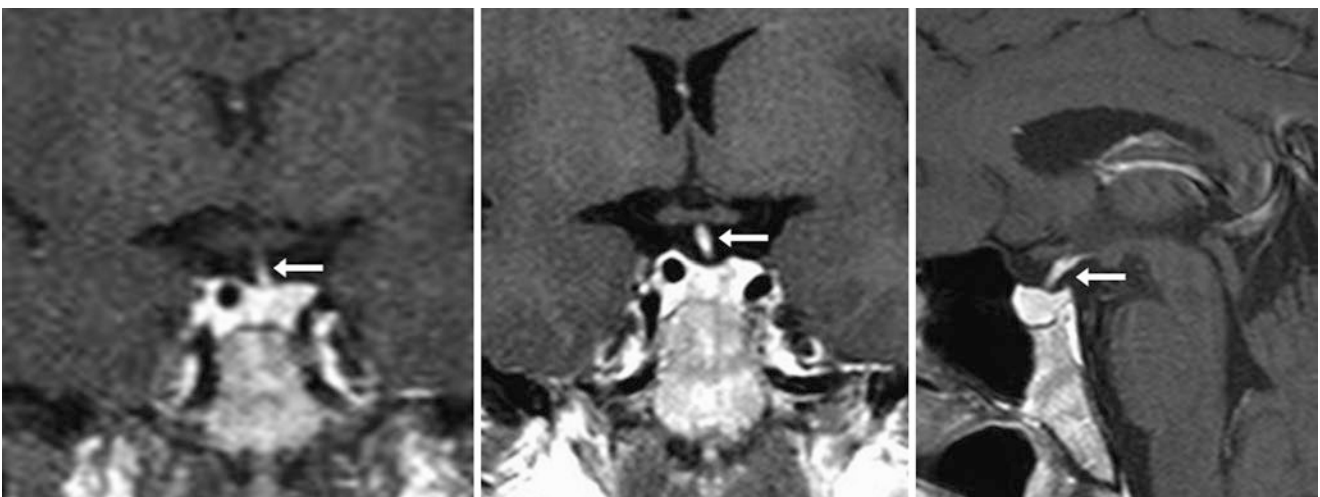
The patient was a 53-year-old female with hypothyroid symptoms (negative MRI). A 1.5 T MRI noted normal, mild infundibular shift to the left (*arrows*) on the 1-min dynamic postcontrast T1WI
